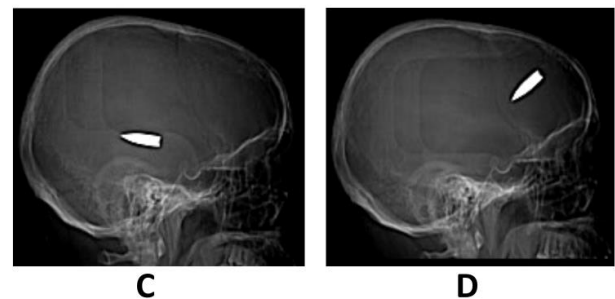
Head x-ray in sagittal view, D: before bullet migration, C: after bullet migration.
